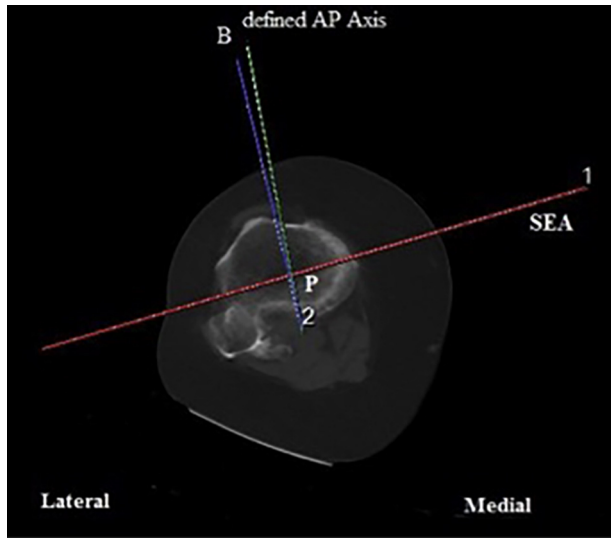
Axial CT image at the same level as Fig. 5, in which angle B is the angle between the AP axis and the line connecting the medial border of patellar tendon to PCL.
